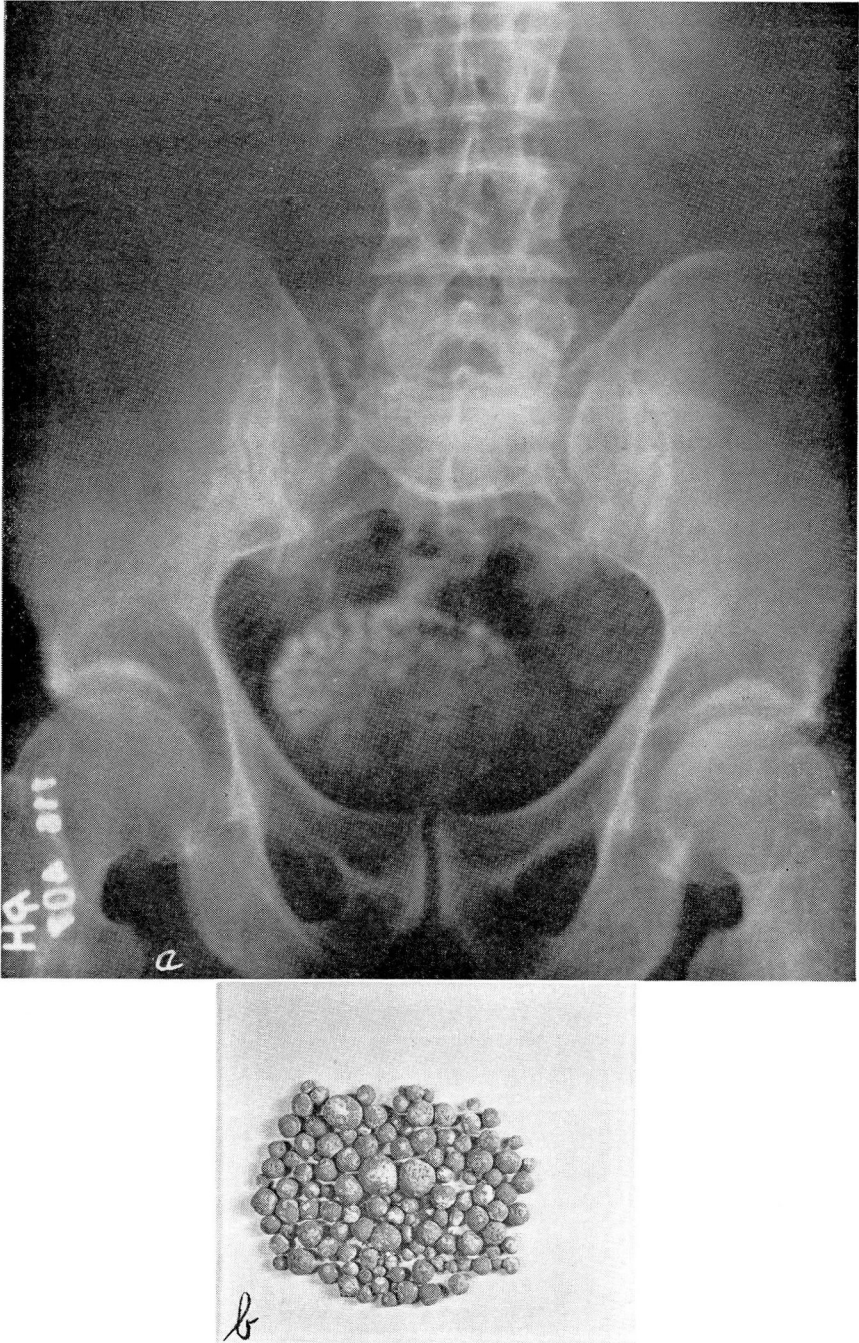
a. Roentgenogram showing multiple calculi associated with benign enlargement of the prostate.
